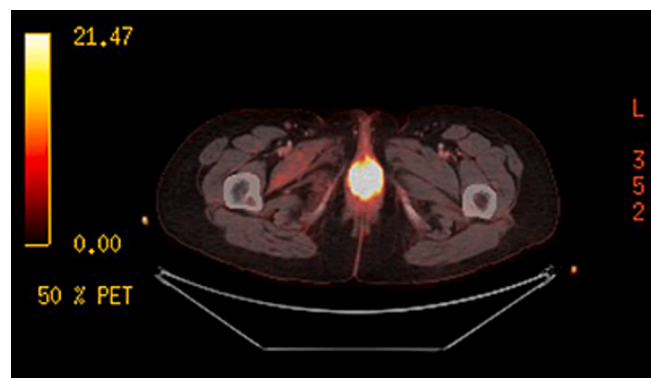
FDG-PET/CT showing local recurrence (on the left) and pathologic right perirenal adenopathies (on the right).
